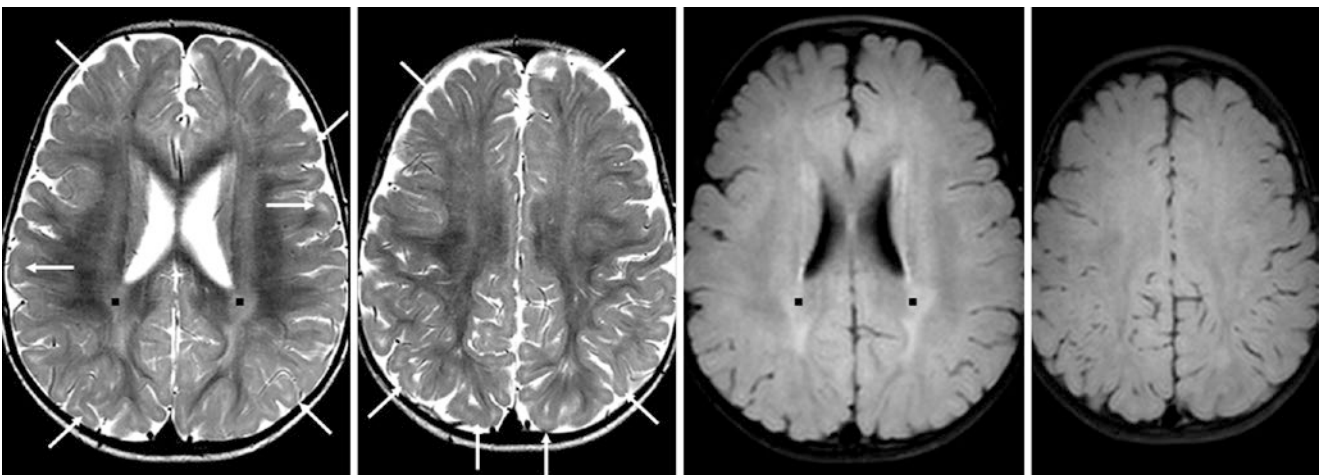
A 14-month-old with mild head enlargement (from slight enlargement of the subarachnoid spaces) had a 3T MRI with SE T2WIs (*left images*) that showed multiple SCWM hyperintense foci (*thin*
